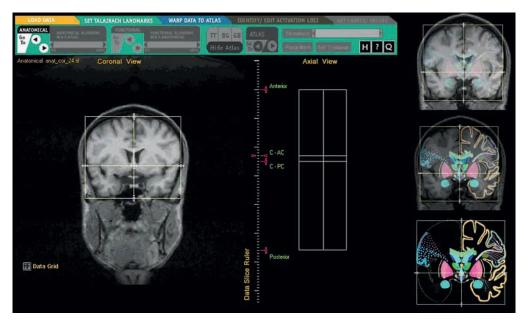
Screenshot from the Brain Atlas for Functional Imaging (BAFI) (Nowinski and Thirunavuukarasuu 2000). Showing the application of a Taliarach coordinate system to a coronal image from a 3D brain MRI. After application of the coordinate space the images can be coregistered to the standard Taliarach map. The images on the *right* show the coregistered images with varying degrees of opacity to demonstrate the image (*top*), the pure atlas (*bottom*) and a fused version (*middle*)
